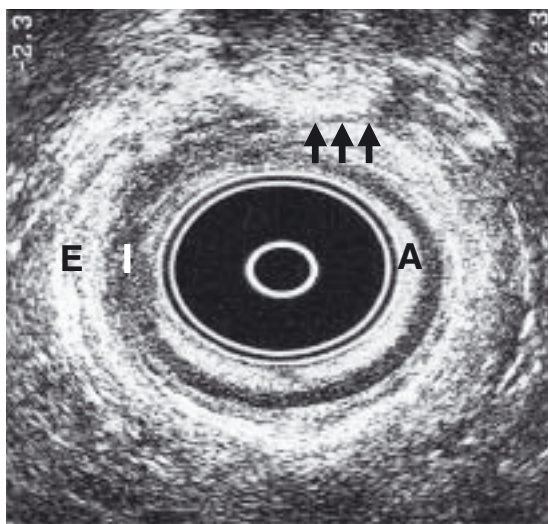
Endoanal ultrasound image (E external sphincter, I internal sphincter, A anal epithelium) with arrows indicating site of overlap repair of the external anal sphincter.
